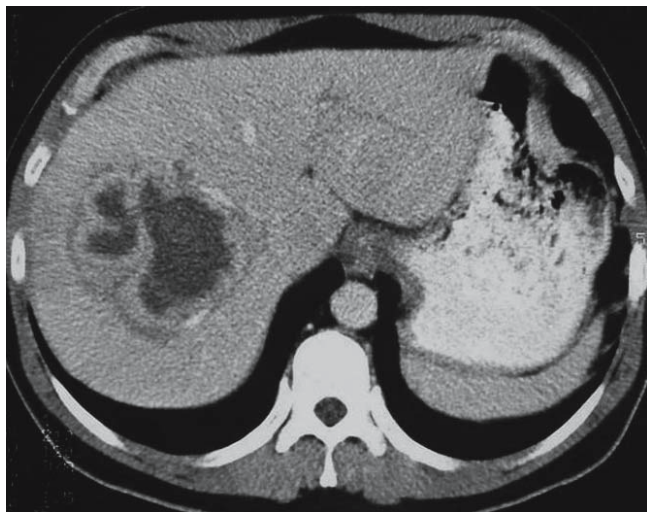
Abdominal CT: intra-hepatic abscess. Note the enhancement of the wall
